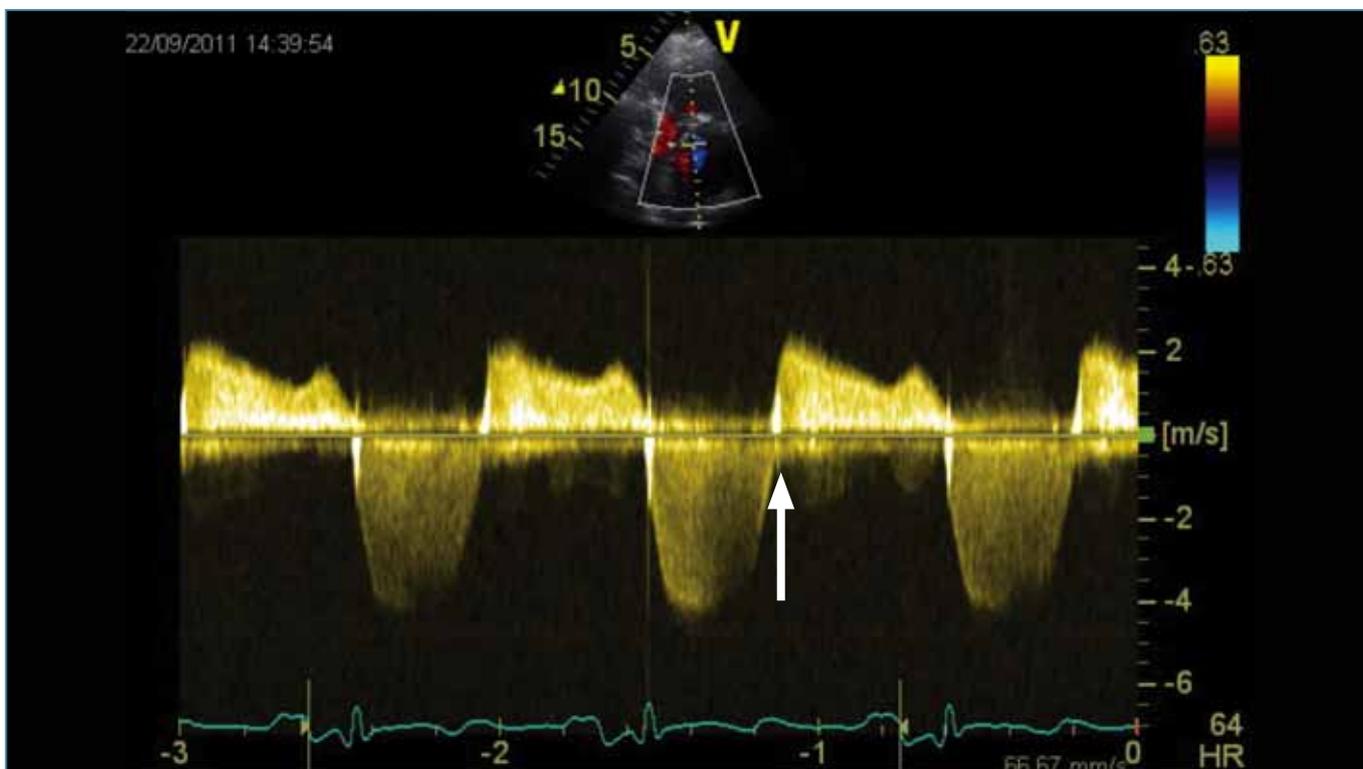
An example of transmitral CW Doppler in a patient with mitral regurgitation (MR). The absence of either an isovolumetric contraction or relaxation period between transmitral forward flow and flow below the baseline identifies the jet below the baseline as an MR jet.
